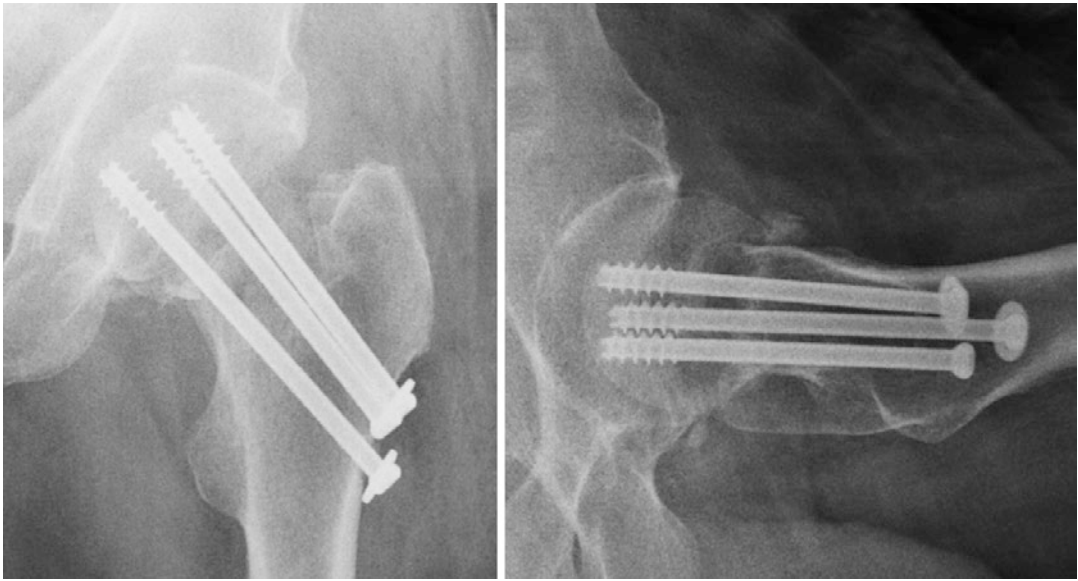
AP and lateral X-ray of the fixation of the femoral neck fracture with three cannulated screws
